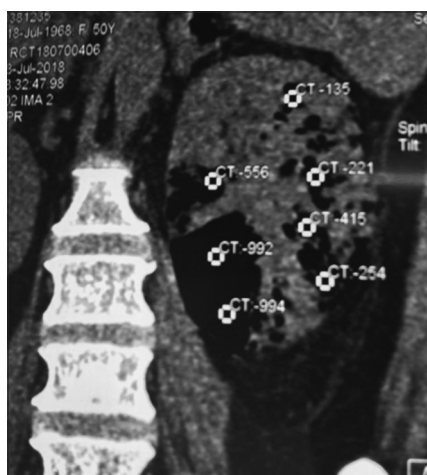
Computed tomography scan showing gas in the pelvicalyceal system and parenchyma with perinephric collection
